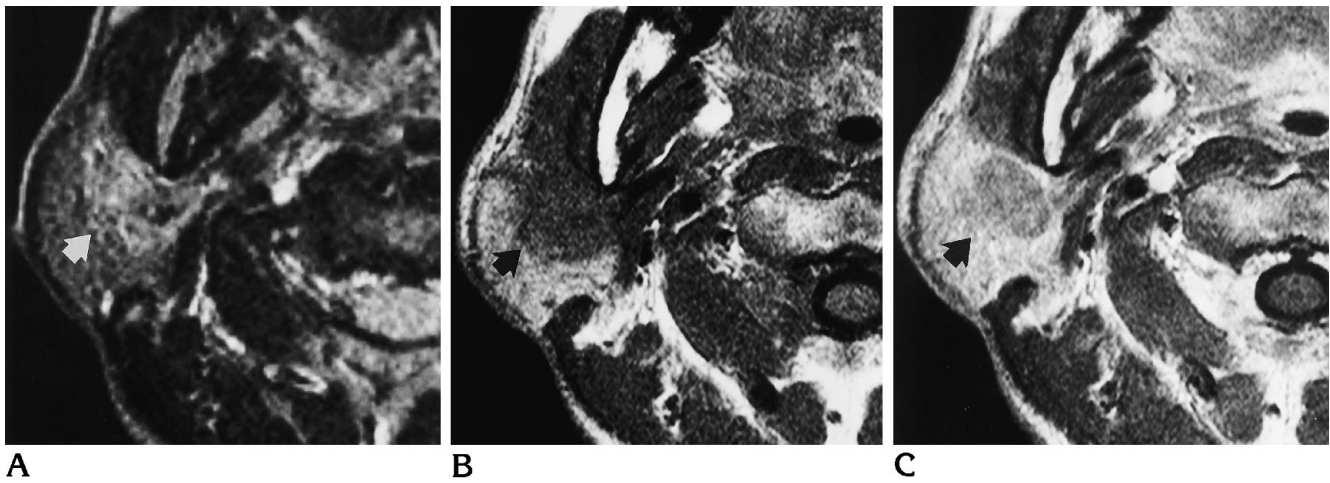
Adenocarcinoma in the deep lobe of the right parotid gland. Axial T2-weighted (2000/80) (A), unenhanced T1-weighted (500/20) (B), and contrast-enhanced T1-weighted (500/20) (C) MR images. The tumor has a poorly defined margin on the unenhanced T1-weighted image (arrow), and enhances less well than adjacent parotid tissue. The capsule is not seen on the contrast-enhanced image (arrow).
